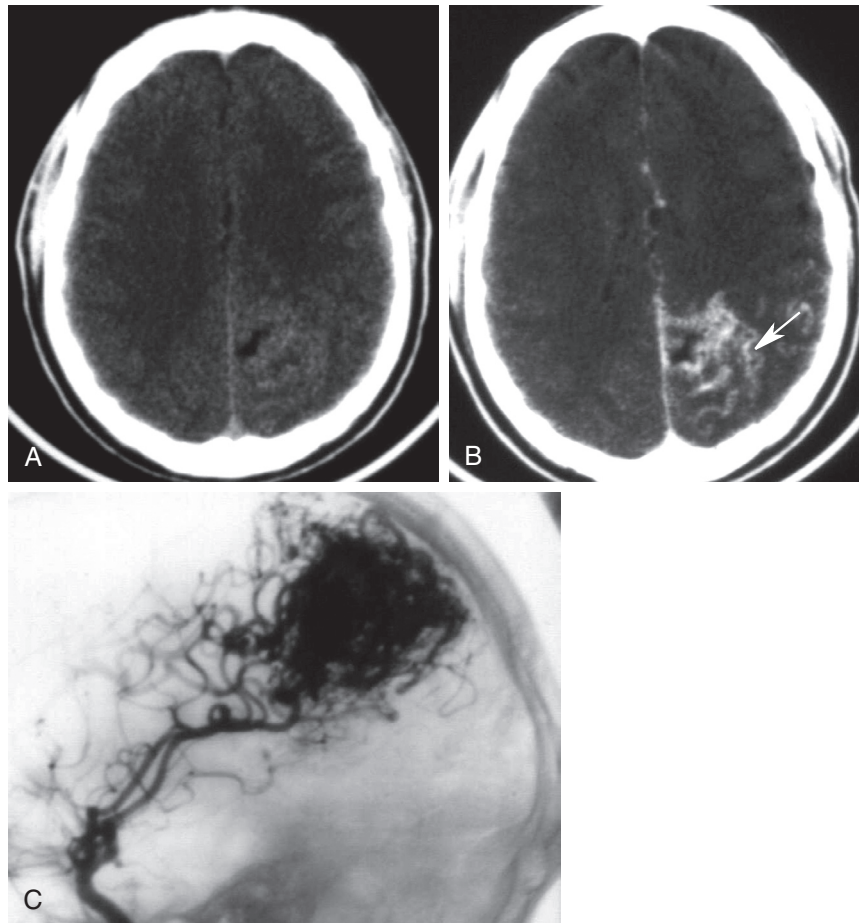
■ Arteriovenous malformation. A, Axial non-contrast-enhanced computed tomography (CT) scan of head reveals a vague area of hyperdensity in posterior left parietal region. B, Contrast-enhanced CT scan demonstrates serpiginous enhancement of this lesion (arrow). C, Internal carotid artery angiogram demonstrates arteriovenous malformation being fed by middle cerebral artery.
